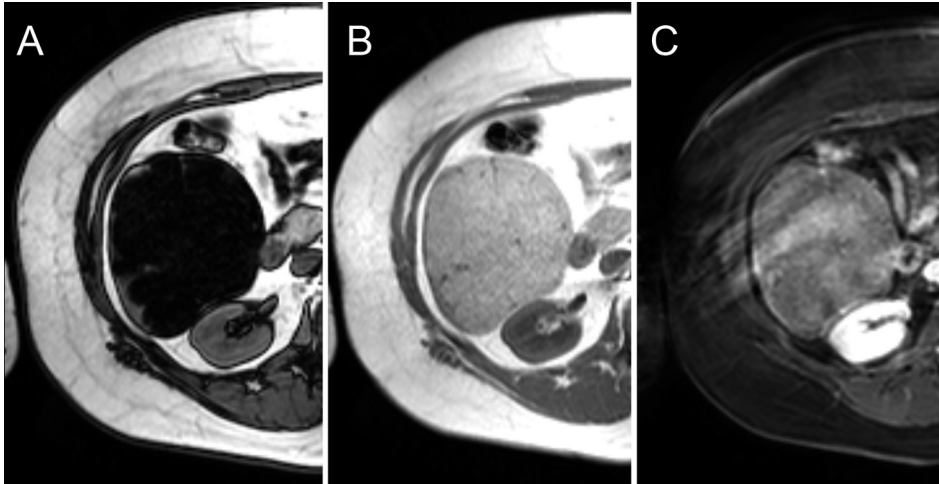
Transverse (a) opposed-phase, (b) in-phase, and (c) contrast-enhanced venous-phase T1-weighted MR images show an L-FABP-negative HCA in segment 5/6, which shows a strong homogeneous drop in signal intensity on a and slight enhancement on c.
